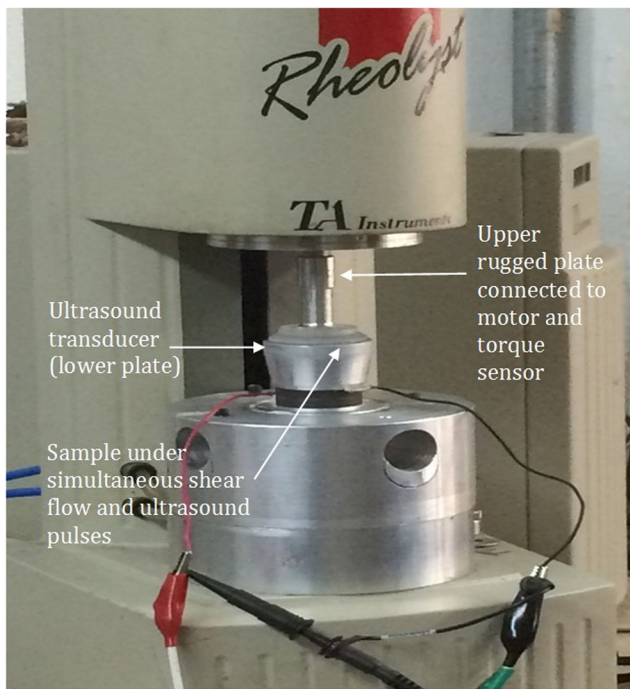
Modified rheometer with fitted ultrasonic transducer
